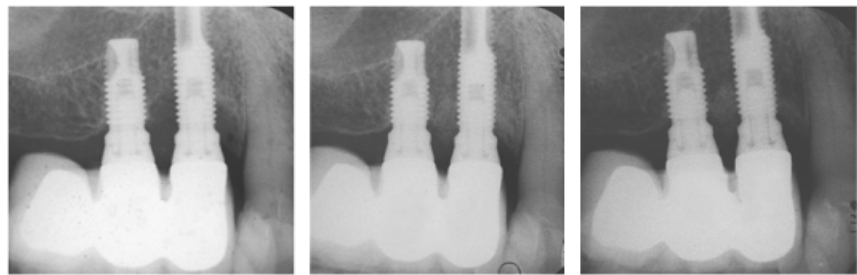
Example of radiographs taken from another subject at baseline, year 1, and year 3 after follow-up.
